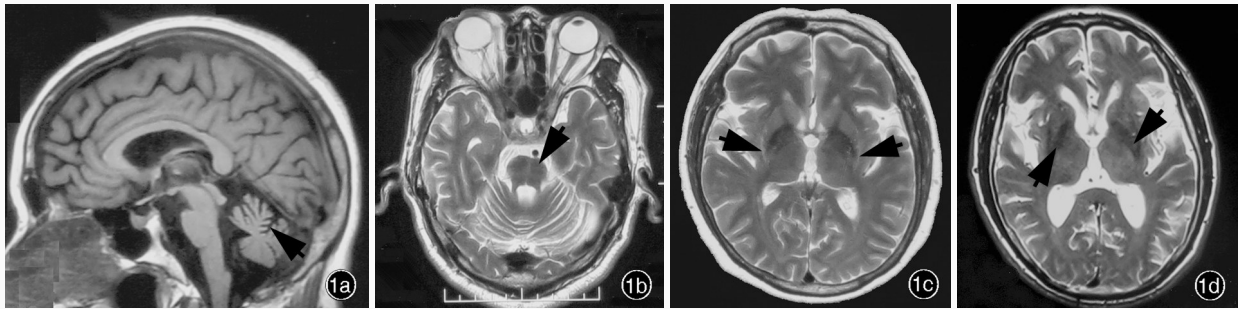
多系统萎缩典型 MRI 表现 1a 矢状位 T₁WI 显示橄榄-脑桥-小脑萎缩(箭头所示) 1b 横断面 T₂WI 显示脑桥“十字征”(箭头所示) 1c 横断面 T₂WI 显示壳核“裂隙征”(箭头所示) 1d 横断面 T₂WI 显示壳核异常低信号(箭头所示)
